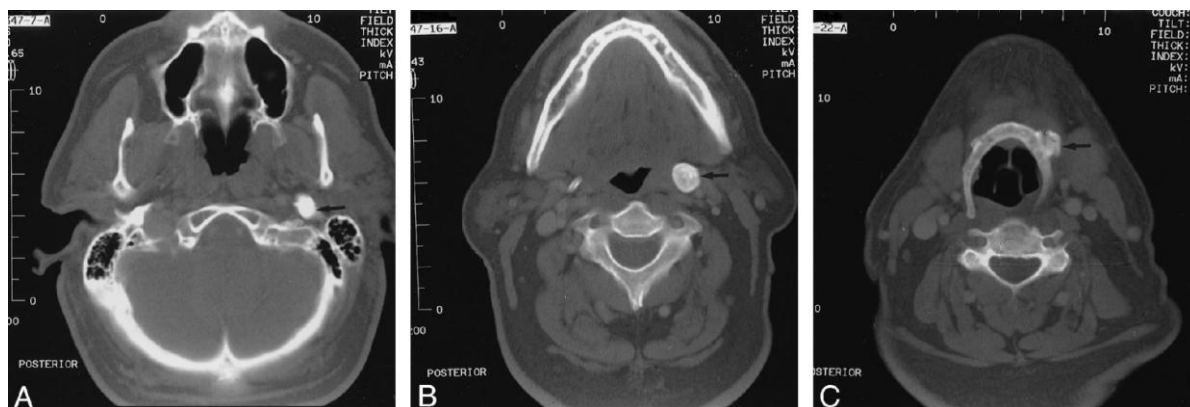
Unenhanced high resolution bone window CT scans of the neck show the heavily ossified styloid process in the axial plane.
